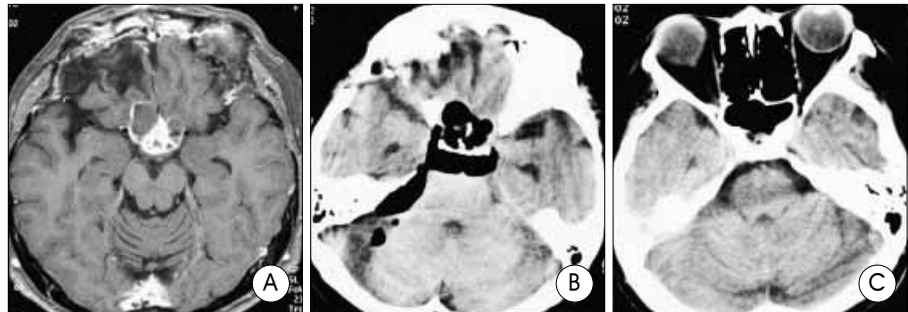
A : Preoperative axial gadolinium-enhanced T1-weighted magnetic resonance image shows a multiple nodular enhancing solid and cystic mass that extend to the third ventricle, and encephalomalacic lesions in right frontal lobe due to the previous operation. B : Computed tomographic scan obtained on the 9th postoperative day shows a large collection of air in the preontine cistern and the basal cistern. C : Follow-up computed tomography scan reveals complete resolution of the intracranial air.
